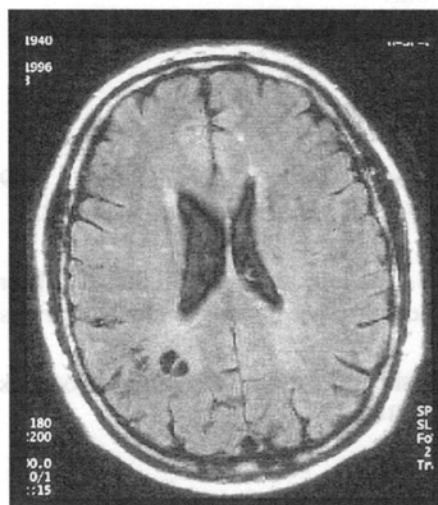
Brain MRI of a diver, showing white matter lesions.
